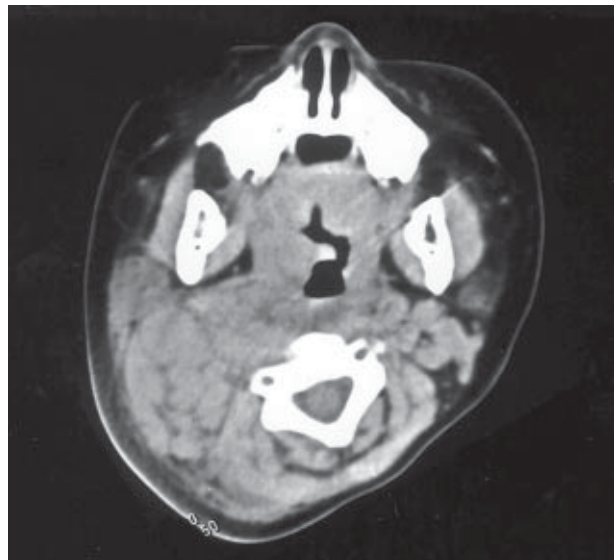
Computed tomography scan reveals massive lymphadenopathy extending into the retropharyngeal region with airway compression.
